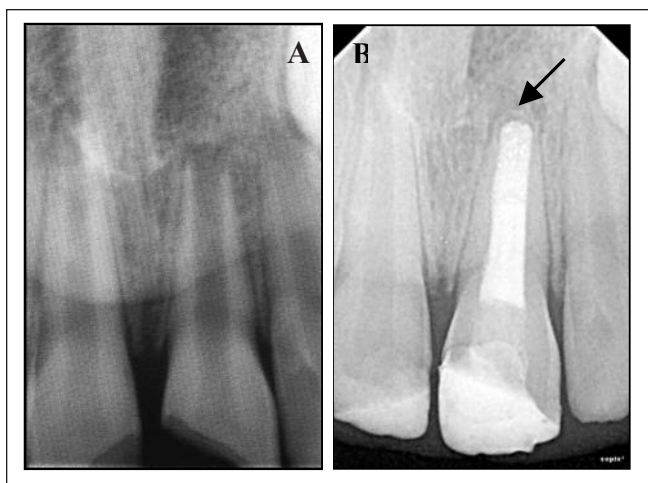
Radiographs showing root end closure with hard tissue formation. A. Preoperative B. 12 month follow up
